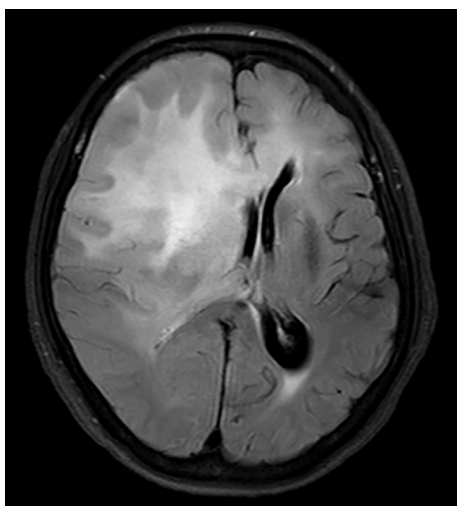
Magnetic resonance imaging (FLAIR) showed an ill-defined mass in the right frontal lobe of the brain that was pathologically diagnosed as anaplastic oligodendroglioma.
